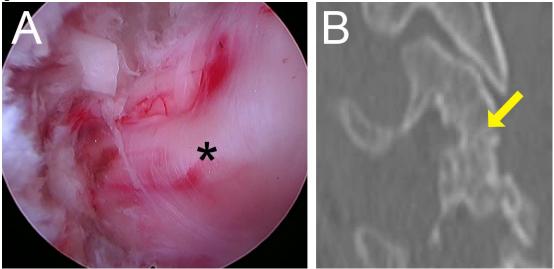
Intraoperative view depicting a decompressed C7 nerve root by an endoscopic C6/7 foraminotomy. Note the demarcation of the dorsal and ventral root (A). A CT scan reveals successful arthrodesis of the C6/7 onlay fusion using ViviGen.
